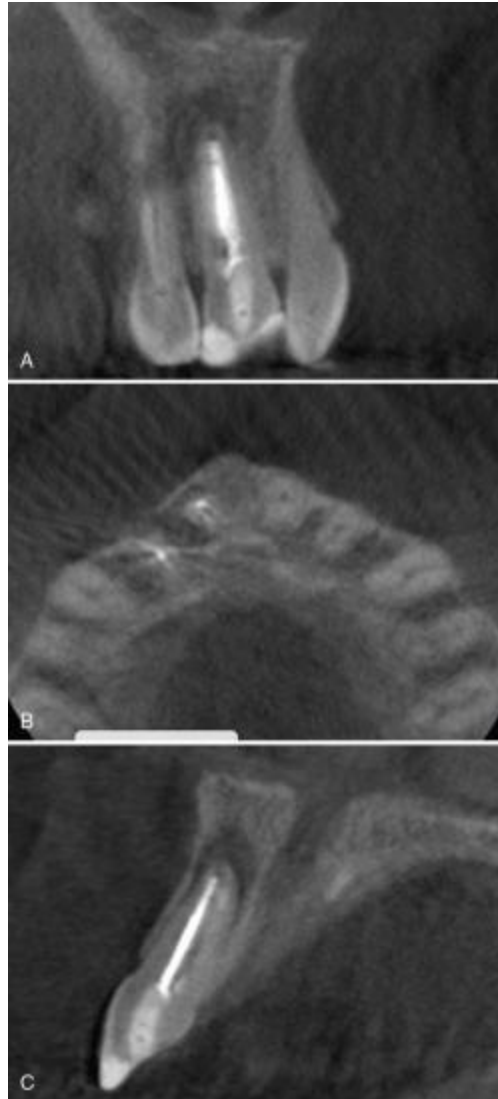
CBCT images of the periapical granuloma from Fig. 3.32, A. It is not possible to differentiate periapical cysts from periapical granulomas using CBCT, and biopsy remains the best method to definitively make this distinction. A, Sagittal CBCT image of periapical granuloma. B, Axial CBCT image of periapical granuloma. C, Coronal CBCT image of periapical granuloma.
